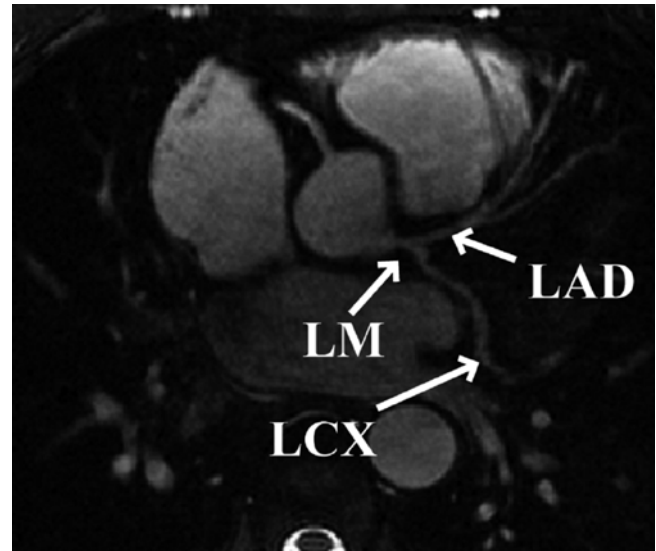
Reformatted coronary MRI of the left coronary system acquired using a targeted free breathing acquisition with real time navigator gating and tracking in a healthy adult subject. The transverse acquisition displays the left main (LM), left anterior descending (LAD) and the left circumflex (LCX) coronary arteries. The in-plane spatial resolution is $0.7 \times 1.0 \text{ mm}^2$
